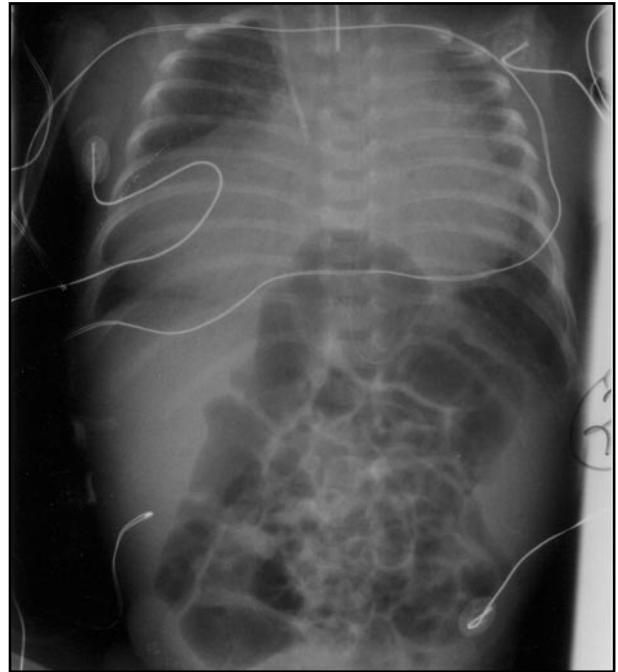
Postoperative chest X-ray showing the right para-cardiac mass and the bowel loops in the lower mid-thorax
